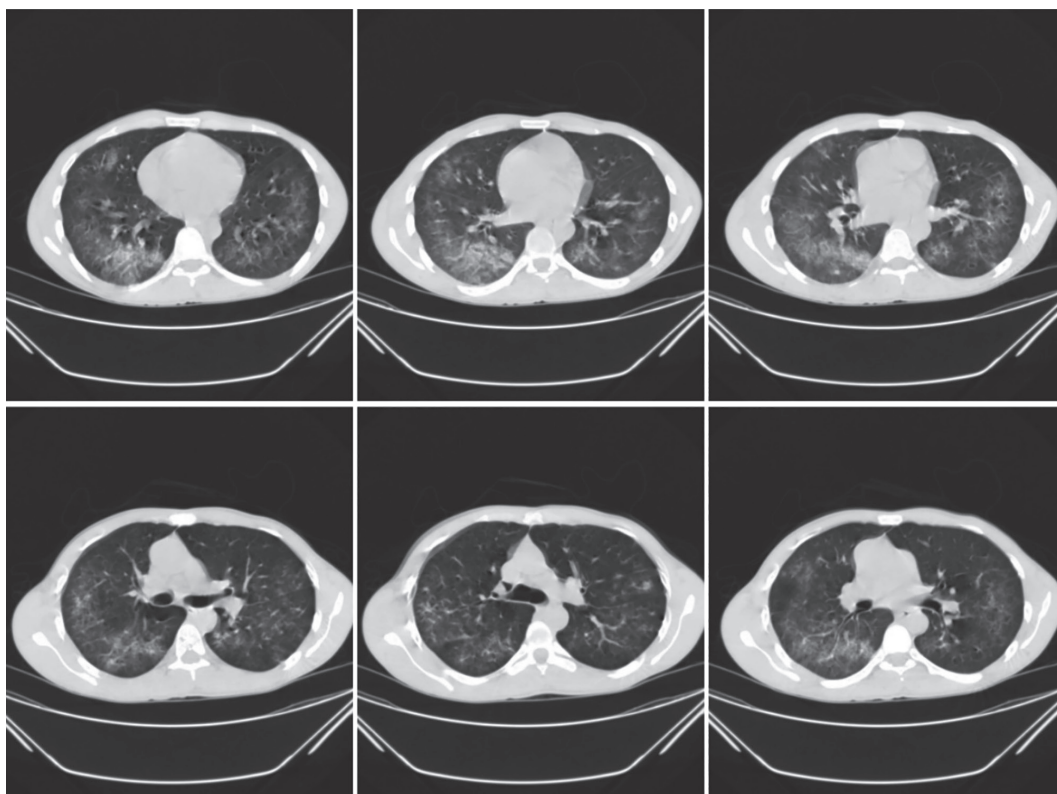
It shows axial mediastinal HRCT.
